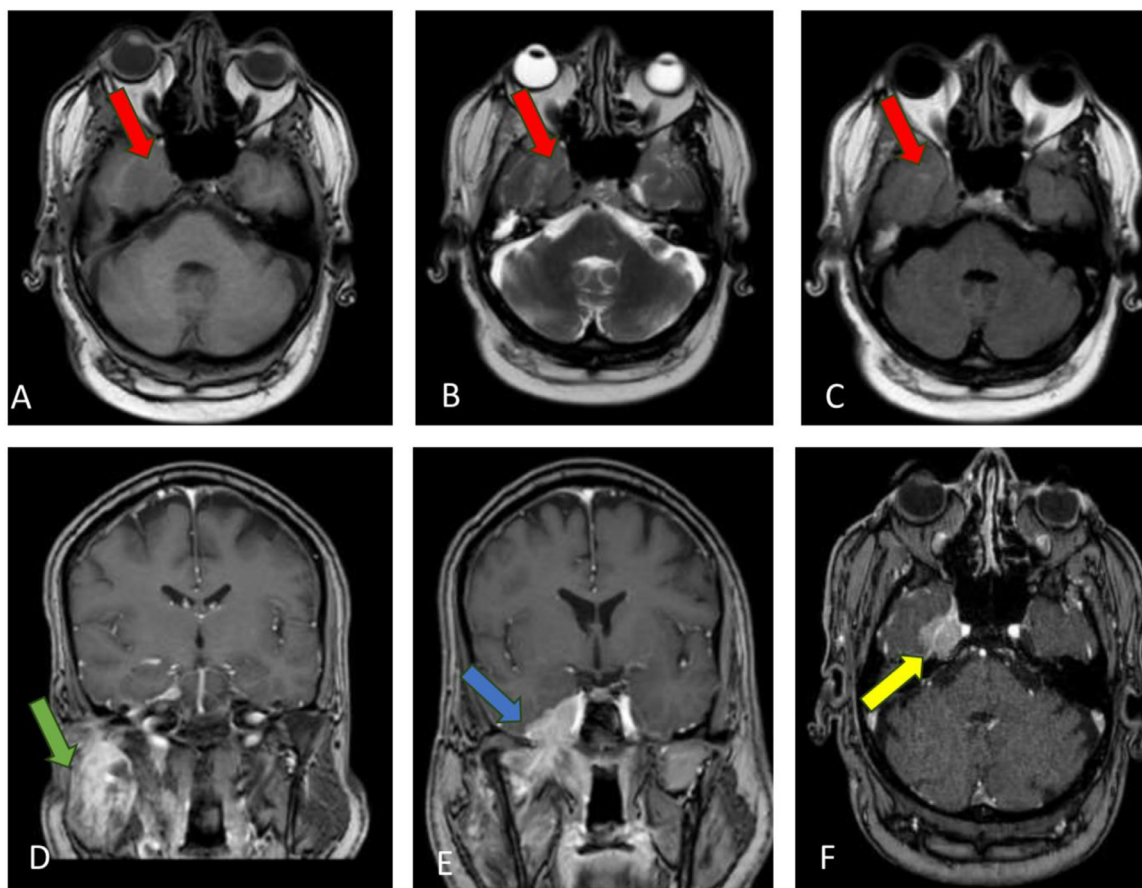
Brain MRI with and without IV contrast; (A) T1-weighted image in axial plane showed isointense lesion at the right temporal region (red arrow), (B & C) T2-weighted and FLAIR images in axial plane showed isointense lesion (red arrow), (D) T1 with IV contrast in coronal plane, showed avid enhancing lesion at the right parotid gland (green arrow), (E) T1 with IV contrast in coronal plane; showed intercranial extension of right parotid gland lesion along the mandibular nerve throw the Foramen Ovale (blue arrow), (F) T1 with IV contrast in axial plane: showed right temporal region extra axial enhancing solid mass representing intracranial extension of right parotid tumor (yellow arrow).
